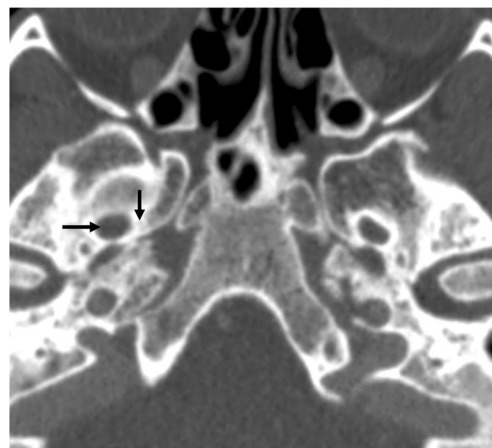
Axial CT, the foramen of Vesalius (vertical arrow) is seen in the right middle cranial fossa, medial to the foramen ovale (horizontal arrow)
